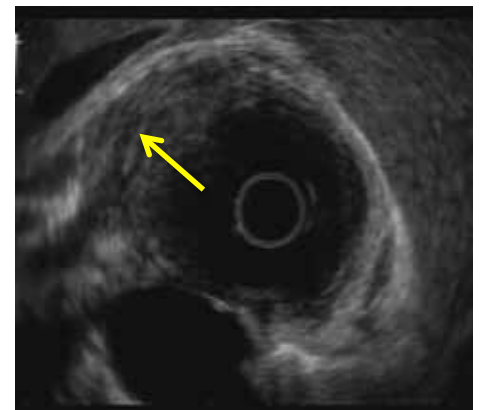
Endoscopic ultrasound showing invasion of a tumor beyond the muscularis propria.
